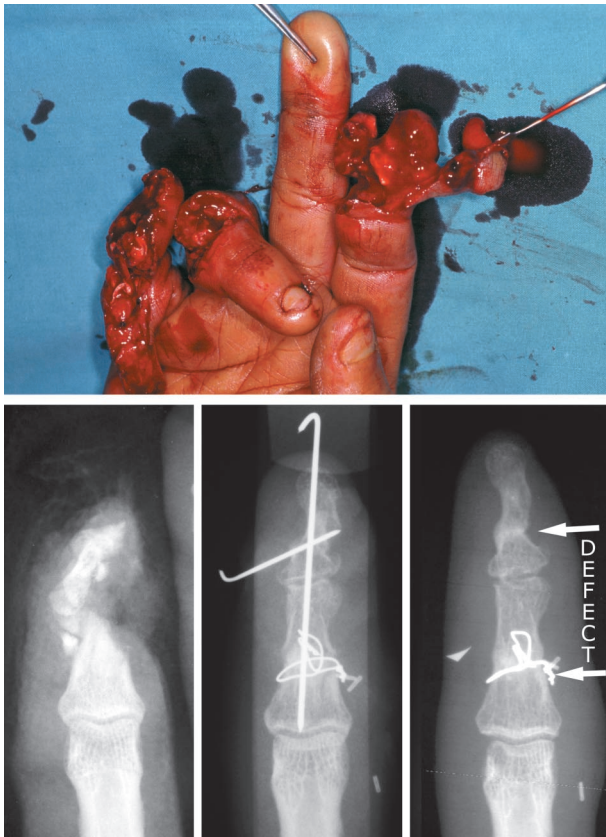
Patient 6. (Above) Preoperative view of a 38-year-old construction worker who sustained a saw injury and was referred primarily. Note amputation of the small finger at the proximal phalanx level and concomitant injury on the ring. (Below) From left to right, preoperative radiograph, and radiographs taken 4 weeks and 1 year postoperatively (arrows point to the defect). Despite the severe damage of the middle and distal portions of the index, the proximal interphalangeal joint is preserved.
